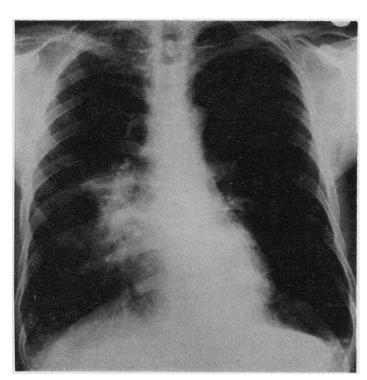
Case 4. Lymphoid interstitial pneumonia. Posterior-anterior radiograph showing infiltrate in right lung.
